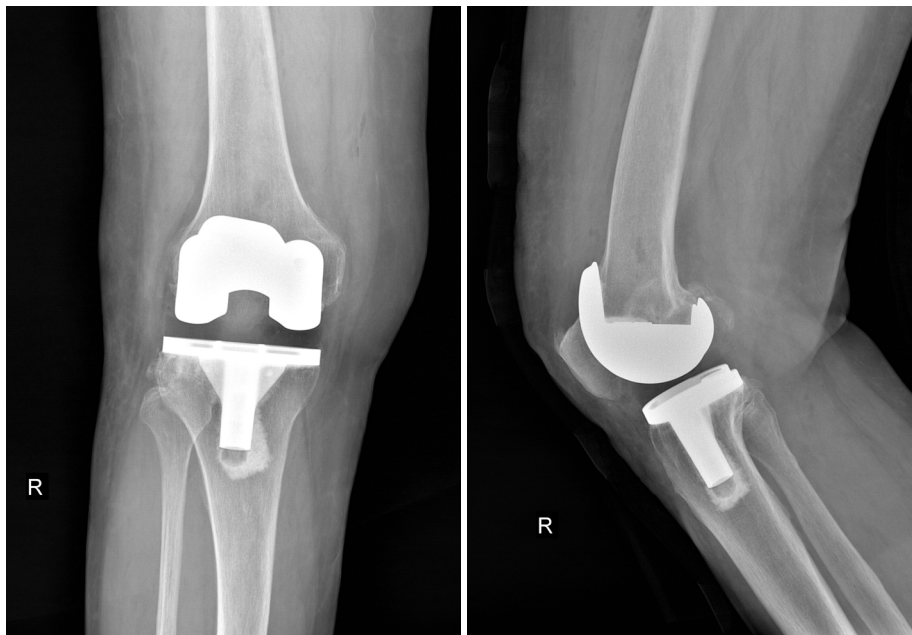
Immediate post-operative anteroposterior and lateral radiographs showing the implant after knee arthroplasty. R, right.
